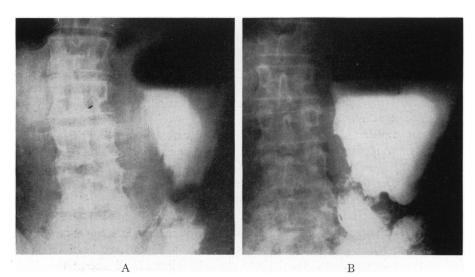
X-ray appearance six weeks after a gastrectomy using a small stoma. It will be noticed in (C) and (D) that there is barium in the proximal loop, this has been pushed back by the radiologist. (A) The barium is seen to run straight through the stoma and into the jejunum after taking the first swallow. (B) Some seconds later the stoma is seen to close and the stomach fills and distends. Note the size and the level of the air bubble.
